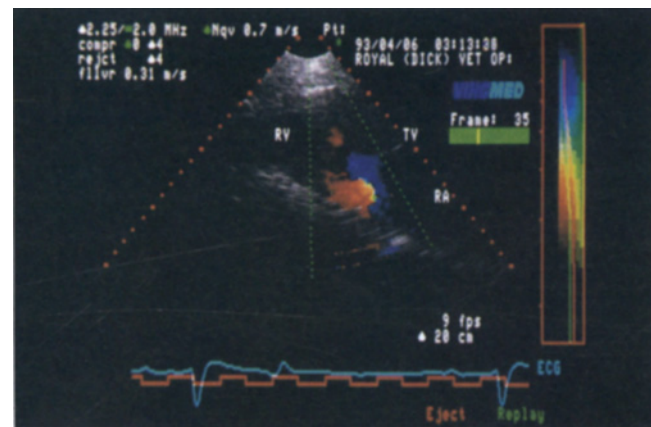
Colour flow study from a right parasternal long-axis view, long-axis aorta, at the onset of systole. The colour flow sector is positioned over the right ventricular inlet. A closure signal coded red and blue with high velocity core is seen at the level of the tricuspid valve.
